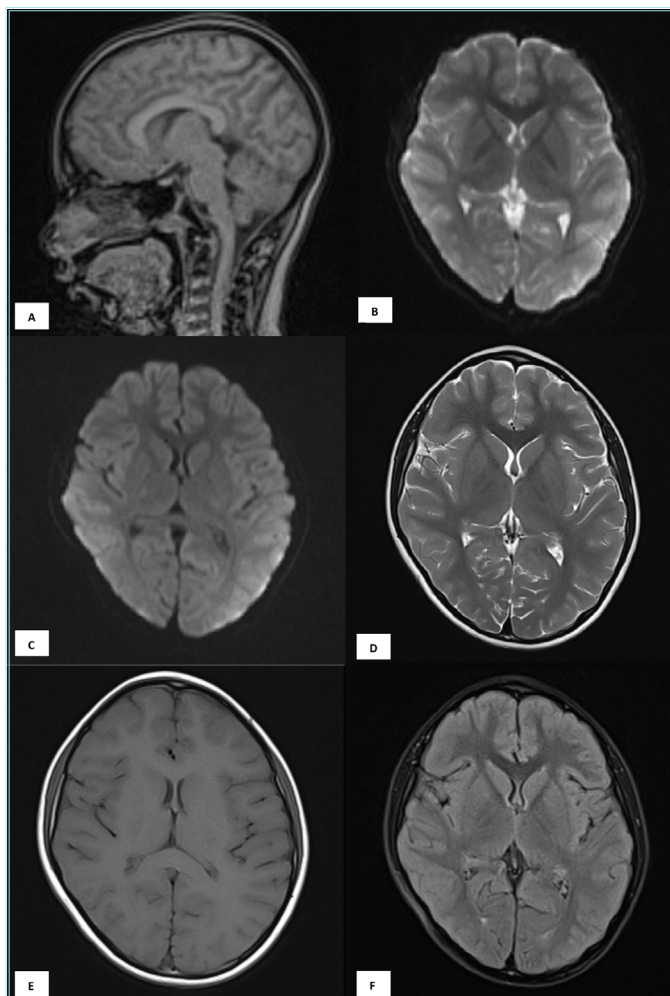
(A-F) Normal MRI brain images in a 10-year-old male child
